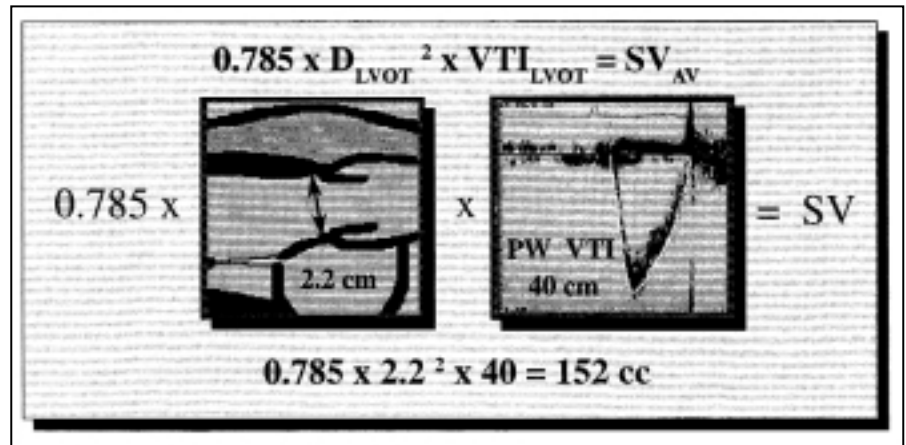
The velocity time integral (VTI) method to estimate ventricular stroke volume uses two-dimensional echocardiography to measure the diameter of the left ventricular (LV) outflow tract and Doppler interrogation of the aortic interval to determine the stroke distance. Measuring the diameter of the LV outflow allows calculation of its cross-sectional area by assuming it is circular. The product of the cross-sectional area and the stroke distance (the distance to the outer edge of the aortic outflow envelope) estimates stroke volume (SV).
